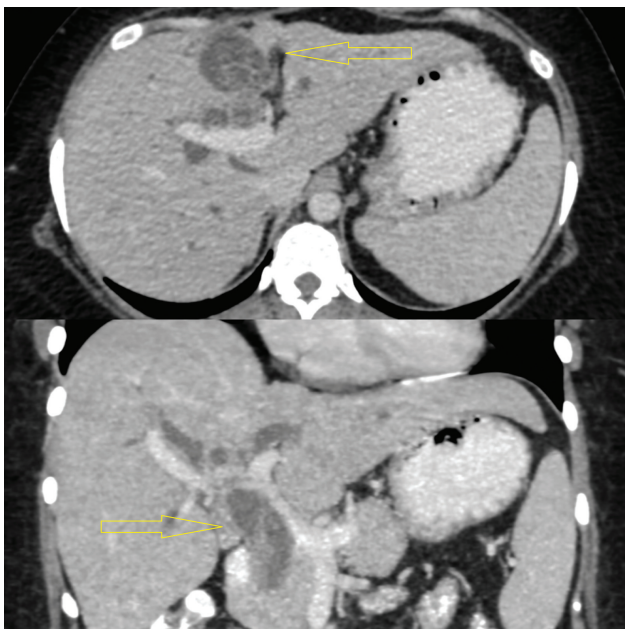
Computed tomography scan showing a cystic lesion involving the left lobe of the liver extending into the dilated common bile duct.
